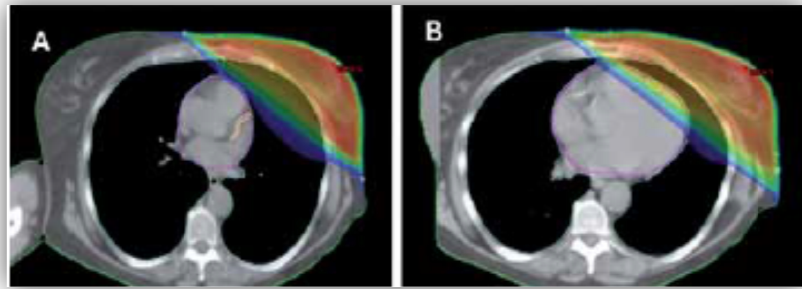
Transverse reconstructions at mid-breast position from the same breast cancer patient. (A) Image from a deep inspiration breath-hold CT and (B) from a conventional CT scan. The cardiac structures are moved away from the chest wall, being pushed in the caudal direction, when the lungs are inflated. The coloured region represents the areas covered by the radiotherapy fields (5).
